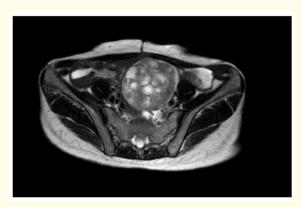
Axial T2-weighted pelvic slice through the left ovarian lesion.
